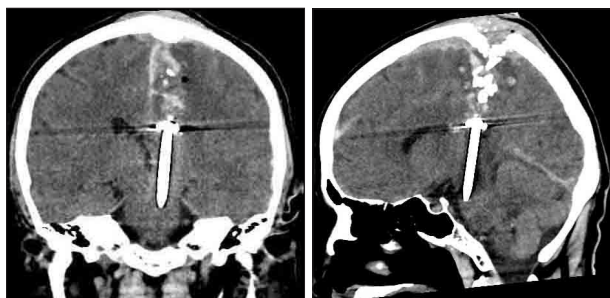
Preoperative coronal and sagittal computed tomography scans reveal a penetrating metallic nail. Multiple fracture fragments are also observed.
